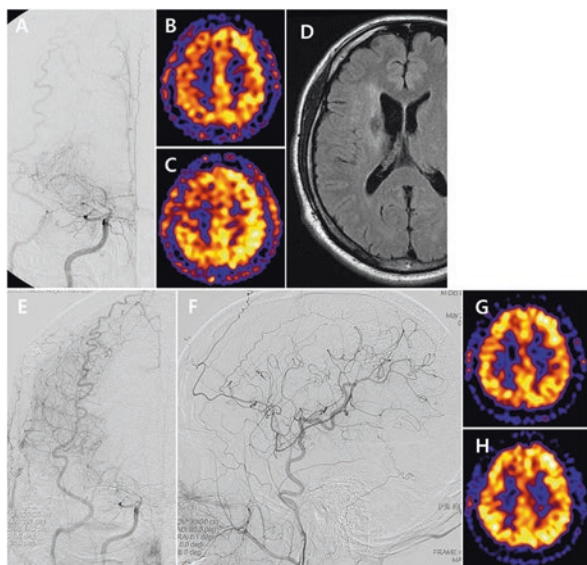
A case of 35-year adult MMD patient treated with right-sided combined bypass surgery (superficial temporal artery angular branch of middle cerebral artery single direct bypass + encephalofaloeosynangiosis). Preoperative evaluation exhibited near occlusion of right distal ICA with limited basal moyamoya vessels on cerebral angiography (a), decrease in basal perfusion (b) and reserve capacity (c) of *right* ICA territory on Diamox® single-photon emission computed tomography, and subacute infarction at the *right* corona radiata on MR imaging (d). On 6-month follow-up work-up, abundant revascularization dominantly by direct pedicle in the territories of ACA as well as MCA (e and f) was demonstrated with a finding of regression of the *right* distal ICA and basal moyamoya vessels (e). In addition, basal perfusion (g) and reserve capacity (h) much improved
